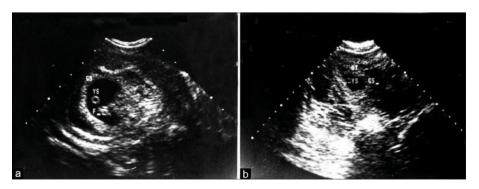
Transvaginal Ultrasound, a: with gestational sac, b: without gestational sac.
